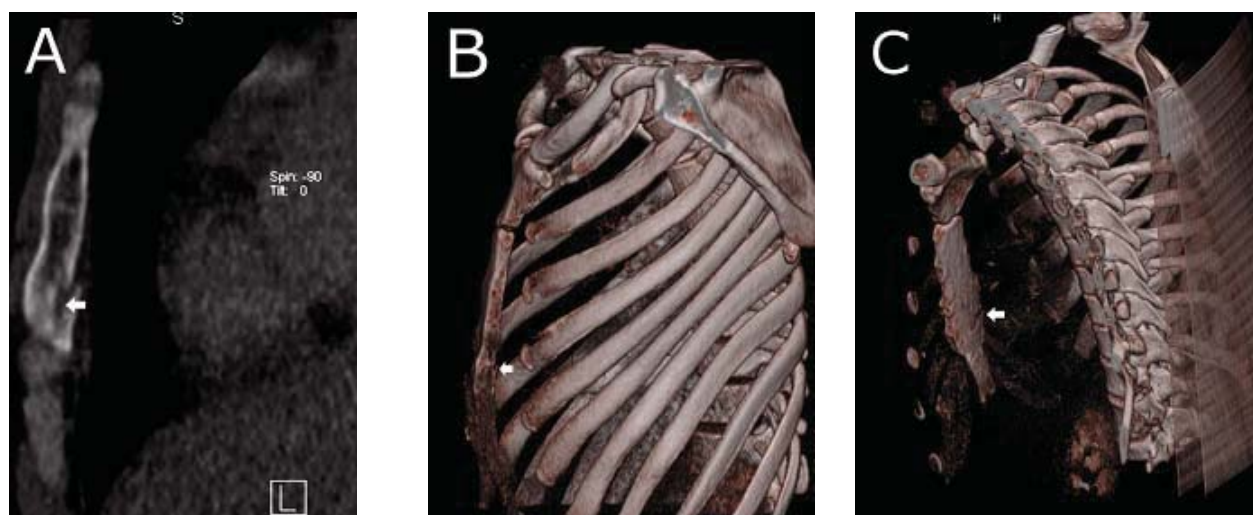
A fracture of the posterior aspect of sternal body (A, B, C arrow). Note the more accurate presentation of the fracture using sagittal reformatted computed tomographic image (A, arrow) compared to volume rendering technique (B, arrow). The fracture was more obvious on volume rendering technique only after the removal of the ribs on the left side in post-processing (C, arrow).
